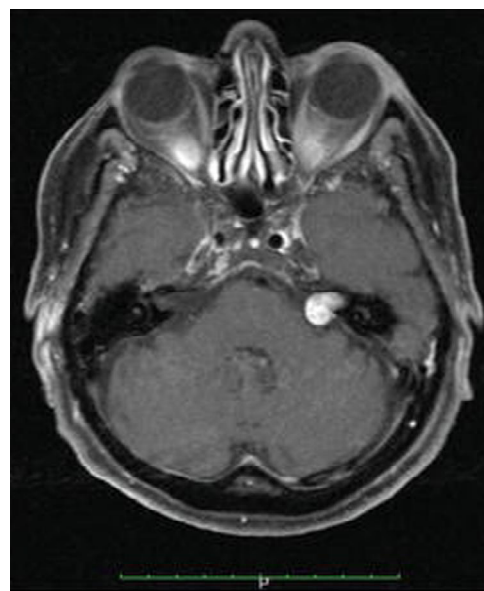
Contrast enhanced axial and coronal T1-weighted MRI showing small VS resembling an ice cream cone in the left cerebellopontine angle.
